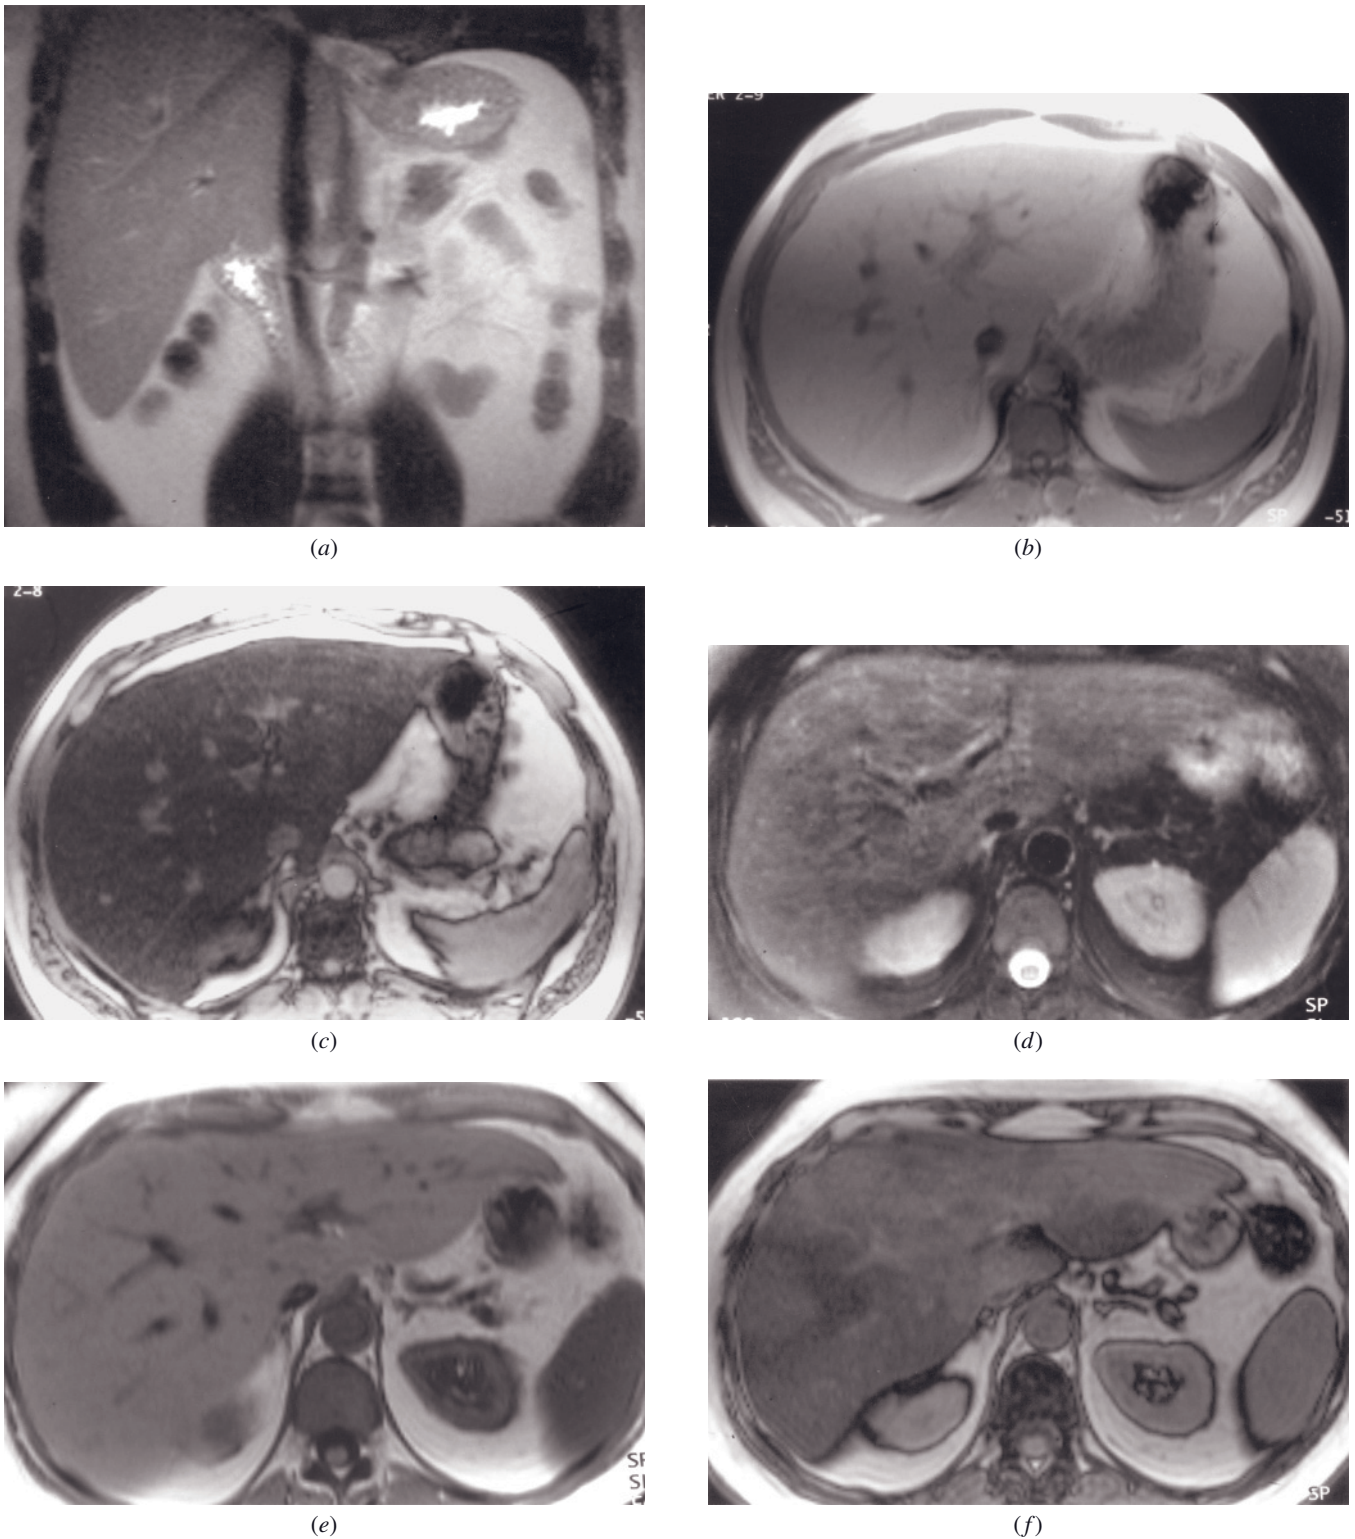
Moderately severe diffuse fatty infiltration. Coronal T2-weighted SS-ETSE (a), SGE (b), and out-of-phase SGE (c) images. The liver is high in signal on T2-weighted image (a), which reflects the fact that fat, including fatty liver, is high signal on long echo-train sequences. A useful internal comparison is the psoas muscle: normal liver should be of comparable signal. Note in this patient that the liver is considerably higher in signal than psoas. In-phase (b) and out-of-phase (c) images confirm moderately severe fatty infiltration.
